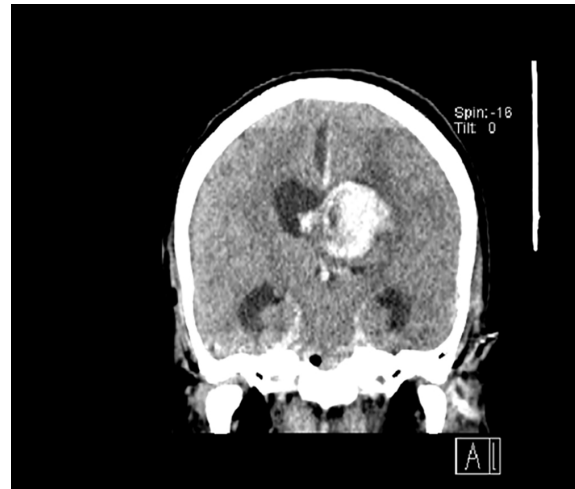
Coronal brain CT scan demonstrates severe intracranial hemorrhage 2 days after tumor resection surgery.
